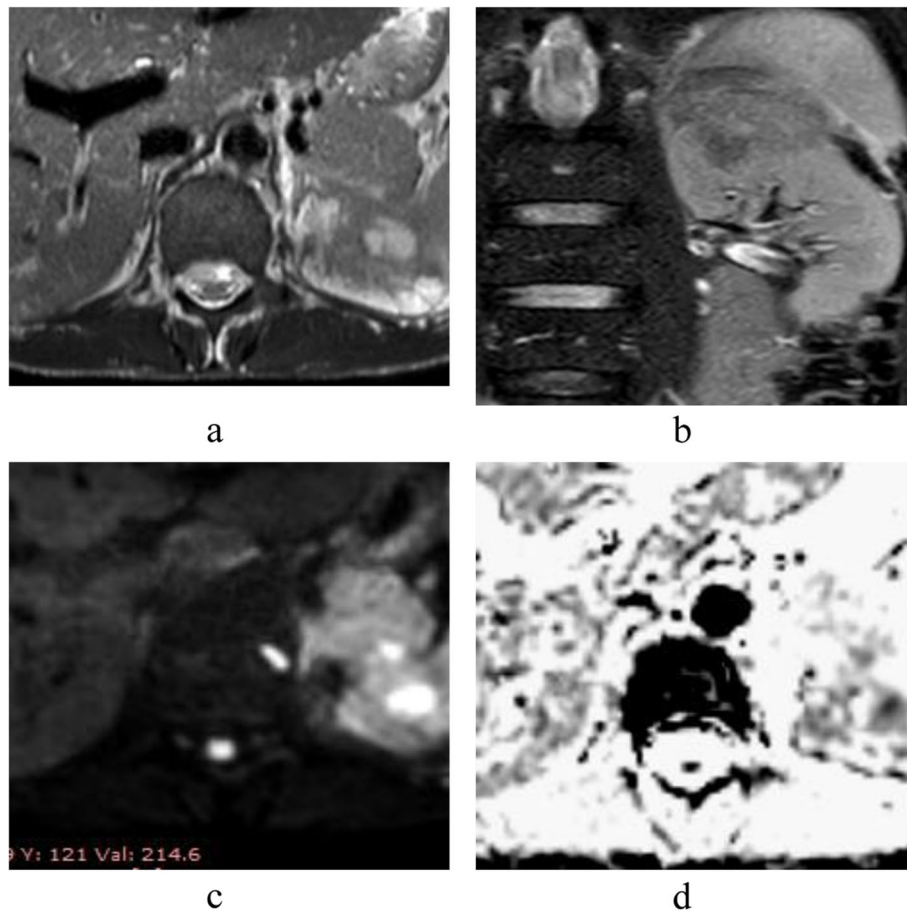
A 43-years-old male coming with left loin pain, fever, malaise. a, b T2 WI axial and sagittal showing a left upper pole heterogeneous lesion with central fluid intensity, c, d DWI with ADC showing restricted diffusion among the central fluid; $ADC = 0.8 \times 10^{-3} \text{ mm}^2/\text{s}$
